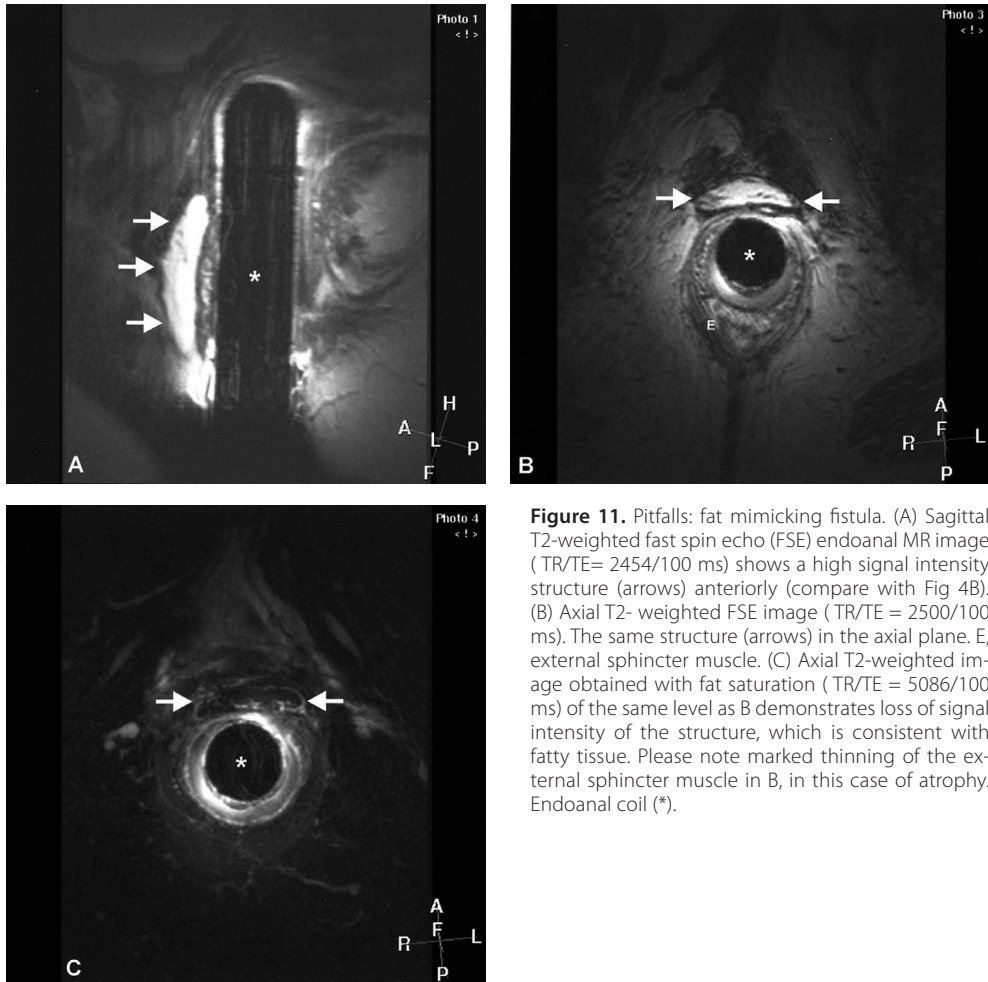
Pitfalls: fat mimicking fistula. (A) Sagittal T2-weighted fast spin echo (FSE) endoanal MR image (TR/TE= 2454/100 ms) shows a high signal intensity structure (arrows) anteriorly (compare with Fig 4B). (B) Axial T2-weighted FSE image (TR/TE = 2500/100 ms). The same structure (arrows) in the axial plane. E, external sphincter muscle. (C) Axial T2-weighted image obtained with fat saturation (TR/TE = 5086/100 ms) of the same level as B demonstrates loss of signal intensity of the structure, which is consistent with fatty tissue. Please note marked thinning of the external sphincter muscle in B, in this case of atrophy. Endoanal coil (*).
